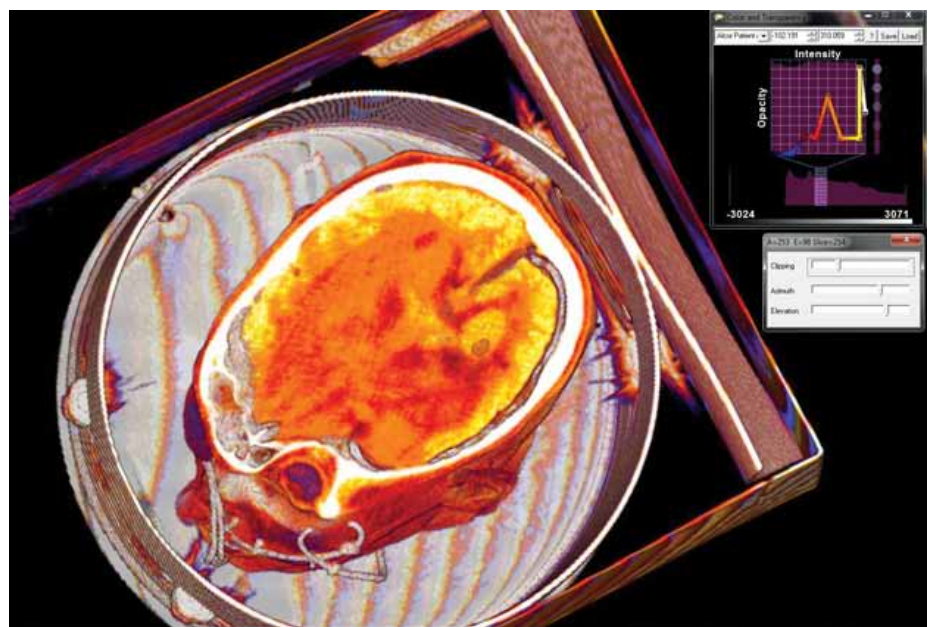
A horizontal "slice" of a CT image at the level of the eyeballs (at the same level as Figure A). Using the CLUT for this image, we presume that darker colors (orange and red) indicate unperfused tissue (i.e., electron densities similar to blood), while lighter colors (yellows and whites) indicate cryoprotected tissue (i.e., electron densities similar to cryoprotectants). Again, we see the same pattern of perfusion impairment of the subcortex with uneven cryoprotection of the cortex.
